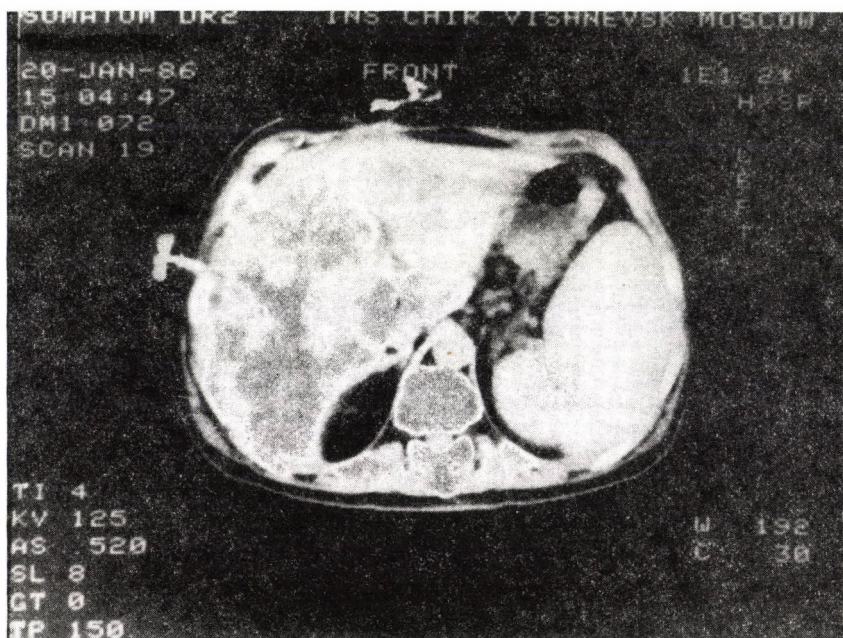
CT scan of a drained abscess on the border of the hepatic segments VI-VII
